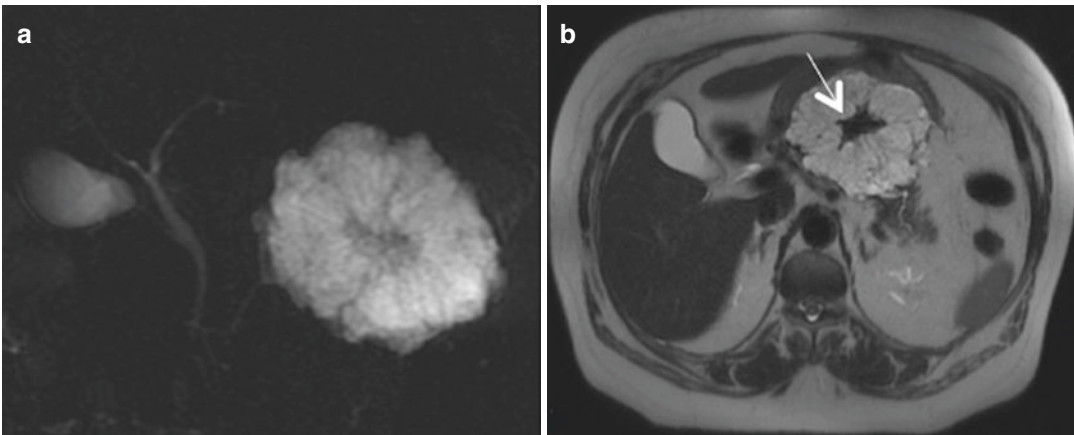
Serous cystadenoma in the body/tail of the pancreas that on (a) 2D-MRCP image does not have communication with MPD and on (b) axial T2-weighted
